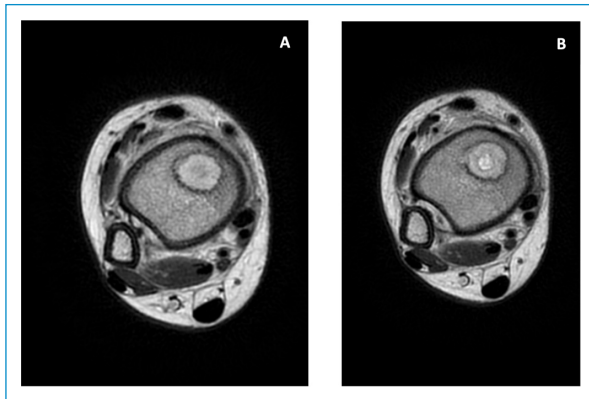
A: ovoid formation on the right ankle surrounded by an irregular wavy contour, with an increased signal on T1-weighted images (and low T2 — penumbra sign). B: accentuated enhancement after administering the contrast, defining four concentric layers, with the central area suggestive of a fluid component.
